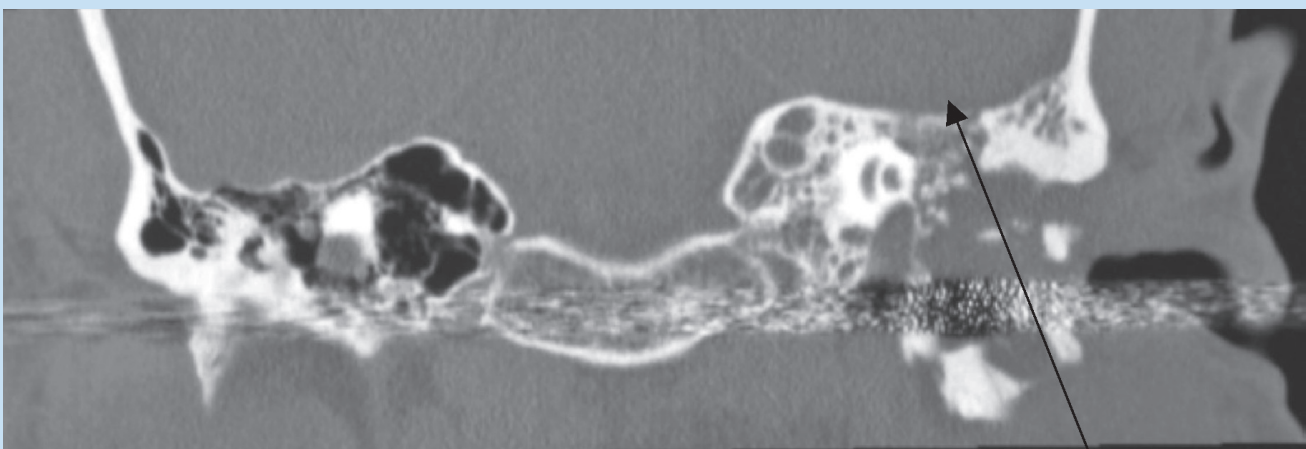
Coronal CT showing the infiltrating cholesteatoma, extending into the middle ear with tegmen tympani dehiscence (arrow).
